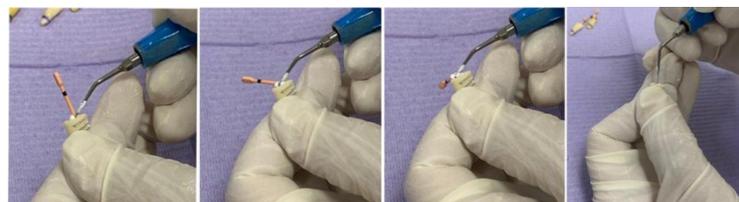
Single-cone obturation with ultrasonic activation of CeraSeal
